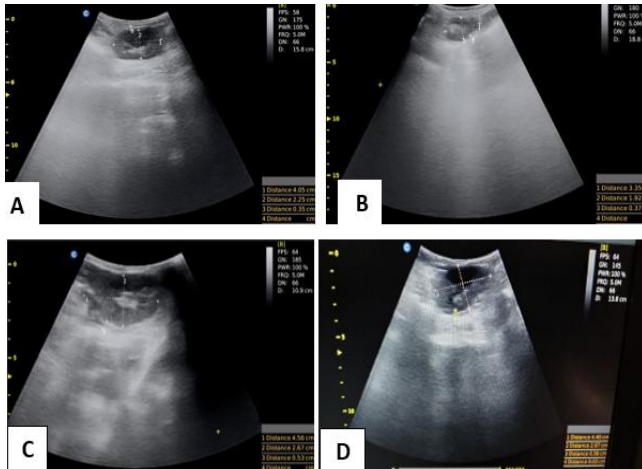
Ultrasonographic images of the remaining kidney showing the differences in its size and the three dimensions on day zero-baseline (A), day 15 (B), day 30 (C), and day 60 (D) following unilateral nephrectomy.
